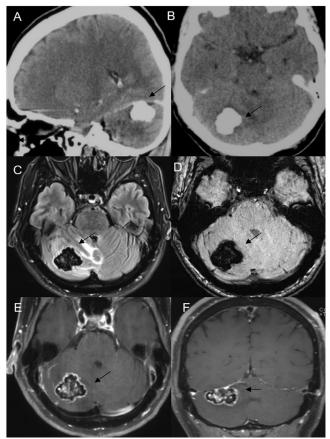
Case 2- Multiple CT images (A,B) reveals a partially calcified lesion in posterior fossa abutting the right tentorium (black arrows). MRI images (C,D,E,F) better characterizes the lesion which shows dark signal on FLAIR (C) with signal-drop out on SWI(D), heterogenous T1 bright signal with no enhancement (arrows) (E,F).Dark signal margins are noted on all sequences including T1 images.
